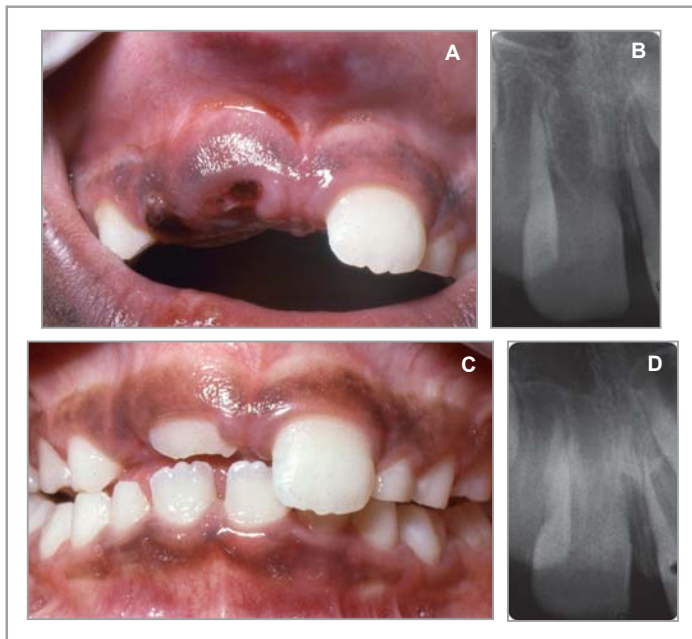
(A) Patient demonstrating intrusion and (B) immature root development that was confirmed radiographic ally. (C) The tooth was left to re-erupt and did (D), which was confirmed radiographically.
